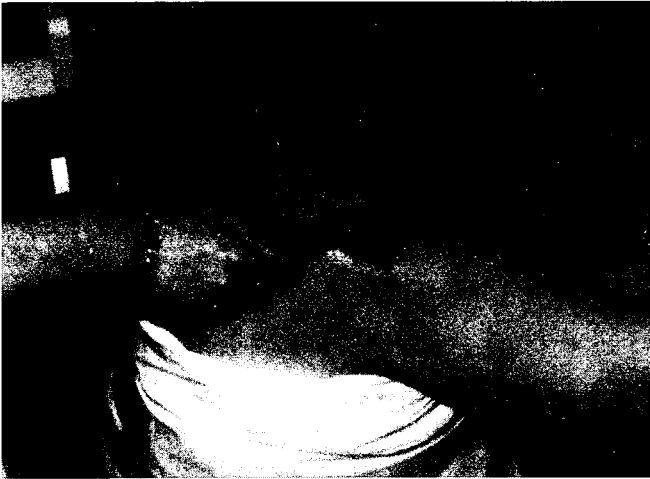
Ultrasound administered for adhesive capsulitis of the shoulder*
